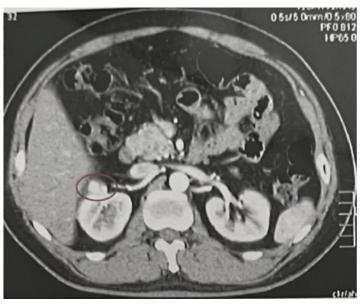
The right kidney mass was measured having: 1.5 x 1.5 x 1.7 cm on the abdominal CT scan.
